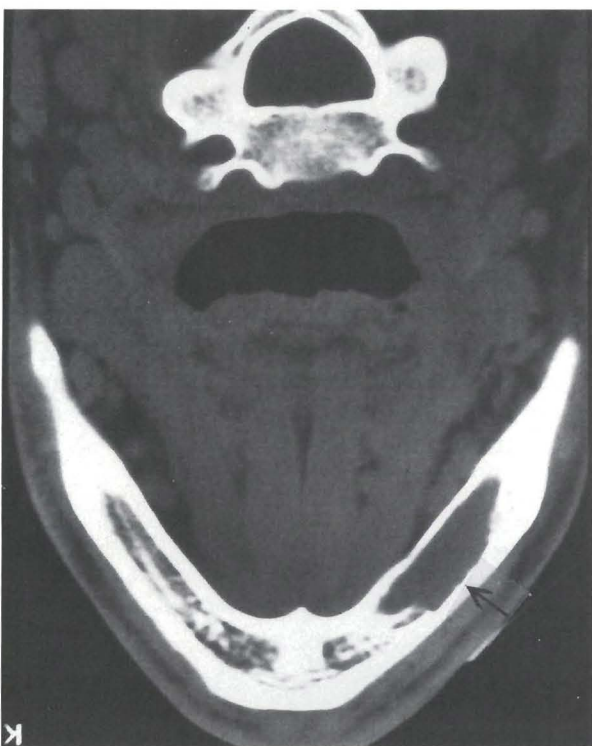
CT scan demonstrating internal cortical erosion of the buccal plate of bone, marrow destruction, and loss of bony trabeculation.
